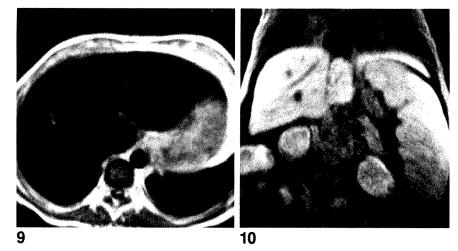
Specificity of T1-weighted image in child with chronic renal disease with multiple transfusions. Axial SE T1-weighted image (500/28) shows markedly decreased signal intensity of liver as a result of iron overload.
